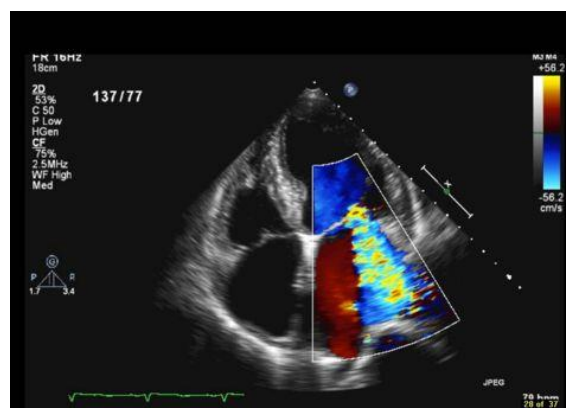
COLOUR DOPPLER IN MR
